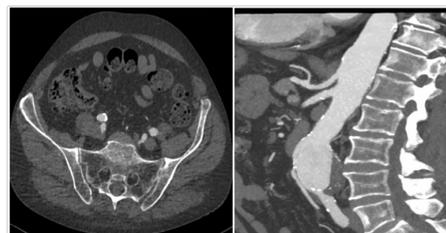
Pre-operative Spiral Computed Tomography (CTA) demonstrates regular patency of visceral vessels, Inferior Mesenteric Artery (IMA) and both hypogastric arteries.
